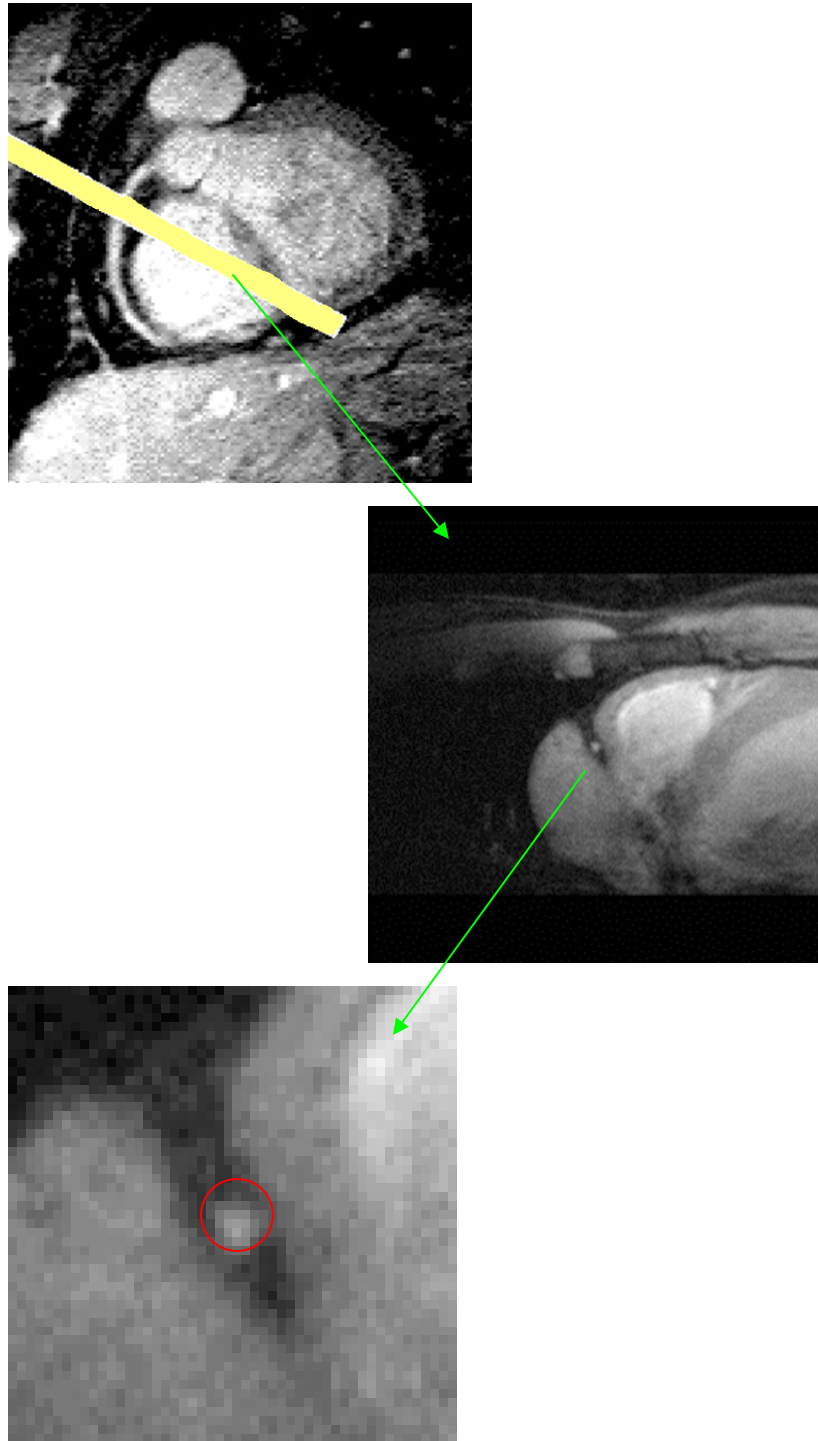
MRI scanning across the right coronary artery; the middle image shows the section of the slice and the low image shows the zoom-in lumen of the right coronary artery.
